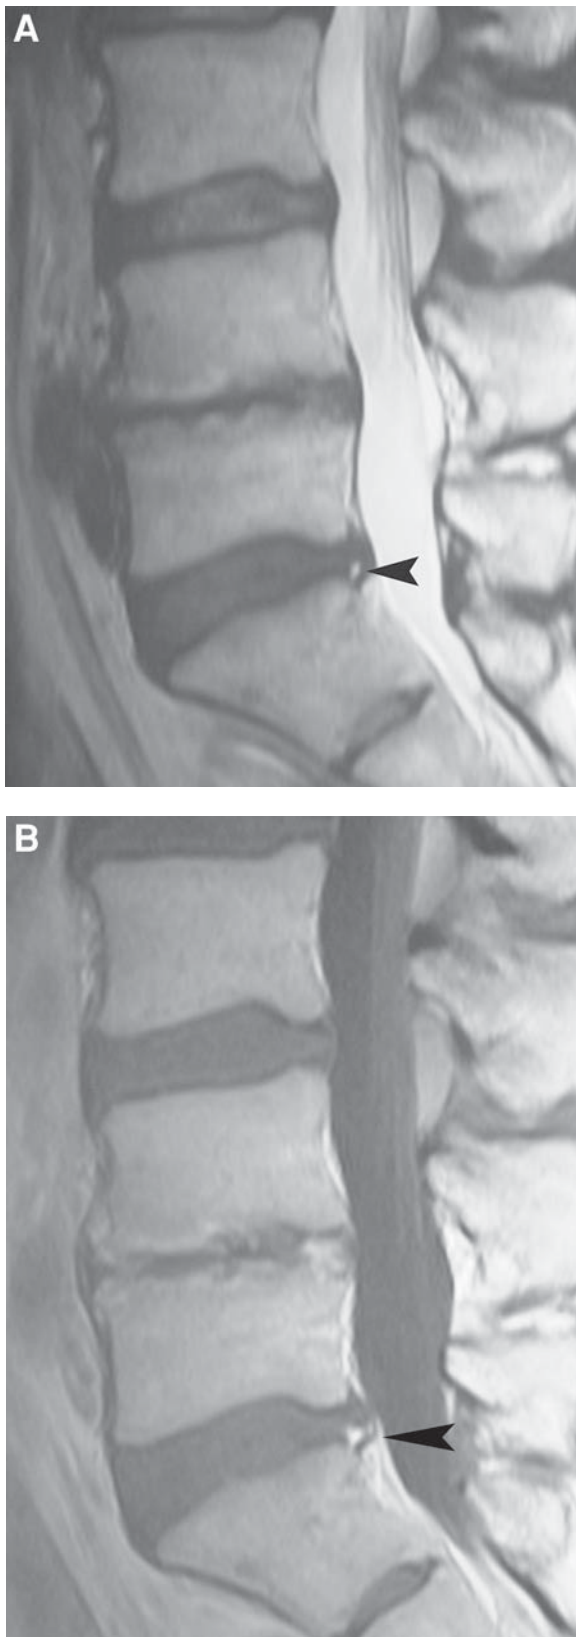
Disc bulge with an annular fissure. Sagittal T2-weighted (A) image shows an L5–S1 disc bulge with a high signal annular fissure (arrowhead) that enhances (arrowhead) on the sagittal T1-weighted post contrast (B) image due to vascularized granulation tissue.
